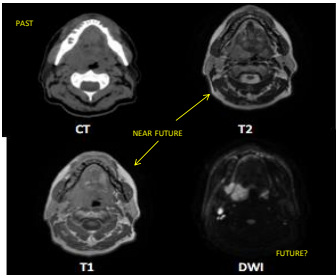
Image modalities with potential for adaptive replanning, showing improved soft tissue contrast with T1/T2 MRI, and POSSIBLE improved tumor recognition with diffusion weighted imaging (DWI)
